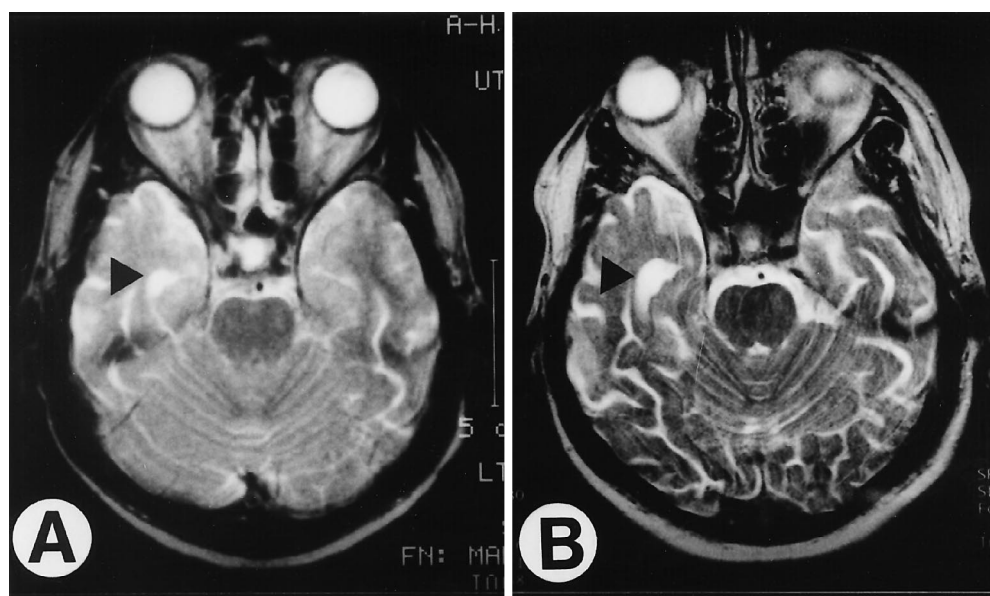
A, B T2-weighted MRI scan of the patient. A At the age of 44 years; B at the age of 49 years. Note the enlargement of the lateral ventricle (*black arrowhead*) due to progradient hippocampal atrophy
